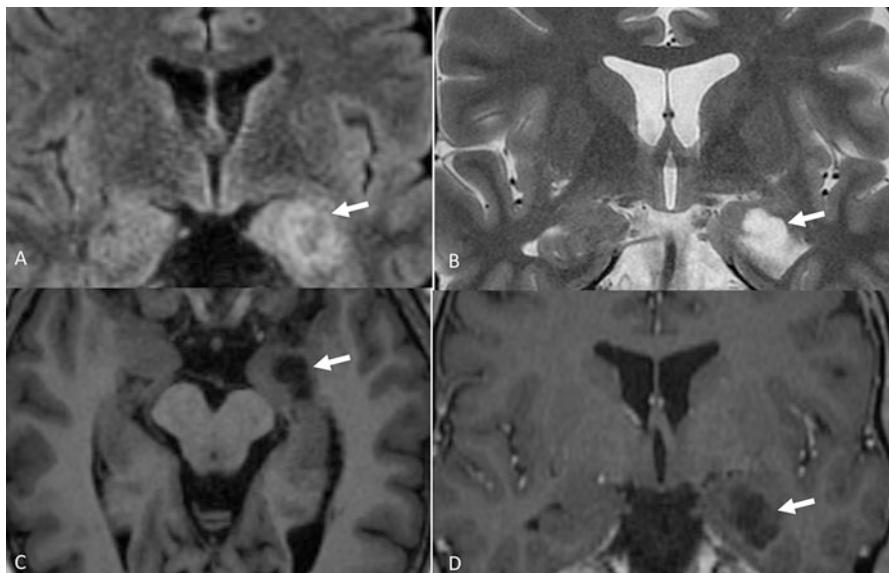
Coronal view in FLAIR (a) and in T2 (b), axial T1 (c), and coronal T1 with contrast media (d) in a patient with left temporal drug-resistant epilepsy. Pseudocystic lesion of the left amygdalo-hippocampal complex without any mass effect. The signal in all sequence is similar to the CSF. Note the thin rim in hyper FLAIR. No enhancement is observed after gadolinium. This aspect is typical of DNET type 1
